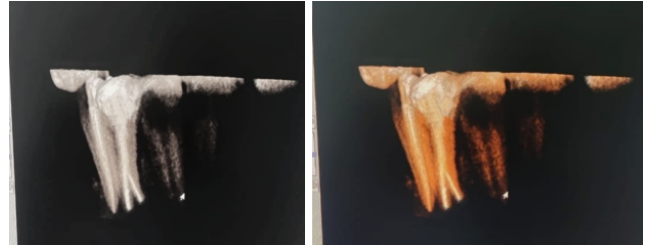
Radiograph of the mandibular right 1st premolar (Post-operative CBCT)
